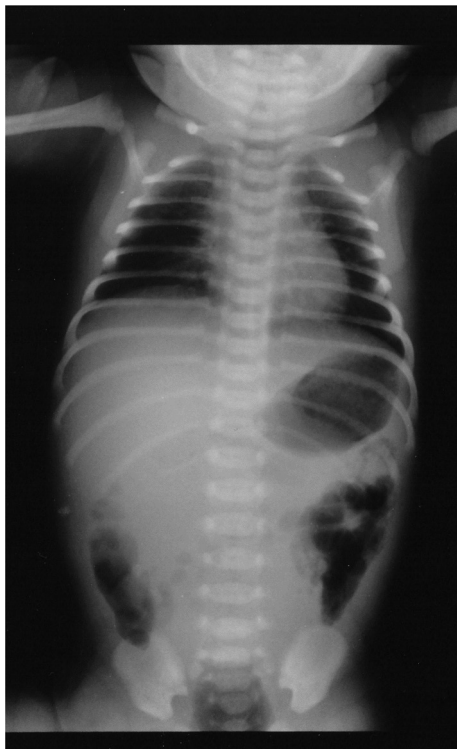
Plain radiograph of the chest and abdomen on admission at 2 hours after birth. The radiograph revealed a homogeneous mass in the mid-abdomen pushing the bowel gasses to the bilateral sides.
